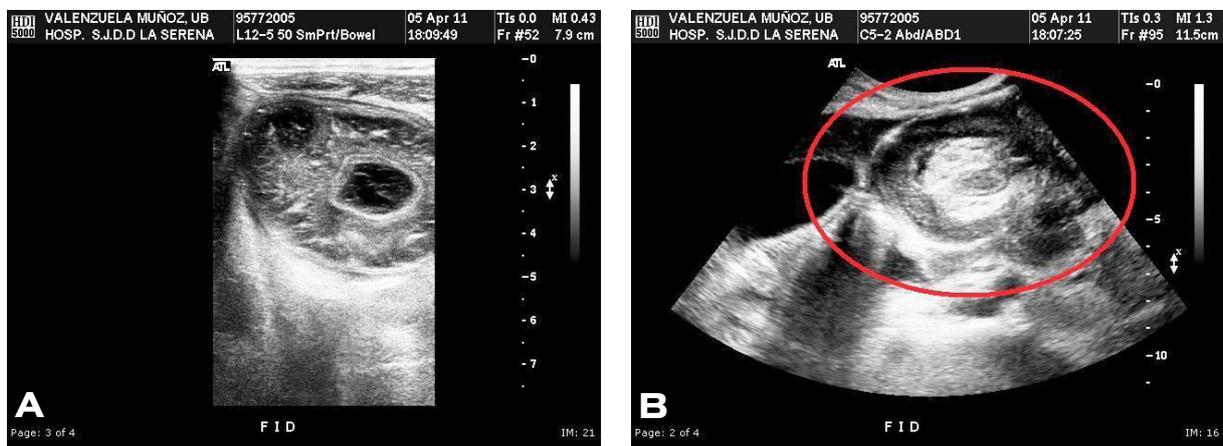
A Abdominal ultrasound focusing over the right lower abdominal quadrant, where the classic “target sign”, also known as the “doughnut sign”, was revealed. These signs are pathognomonic of intussusception. B Longitudinal view showing the “pseudo-kidney sign”, another pathognomonic intussusception sign.
